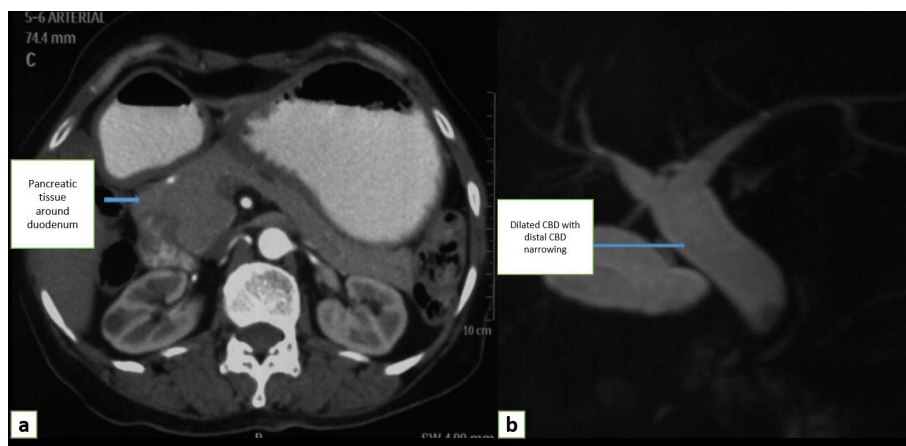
(a) CT (computed tomography) abdomen showing pancreatic tissue around second part of Duodenum (arrow). (b) MRCP (magnetic resonance cholangiopancreatography) 3 dimensional reconstructed image showing dilated CBD with distal CBD stricture
